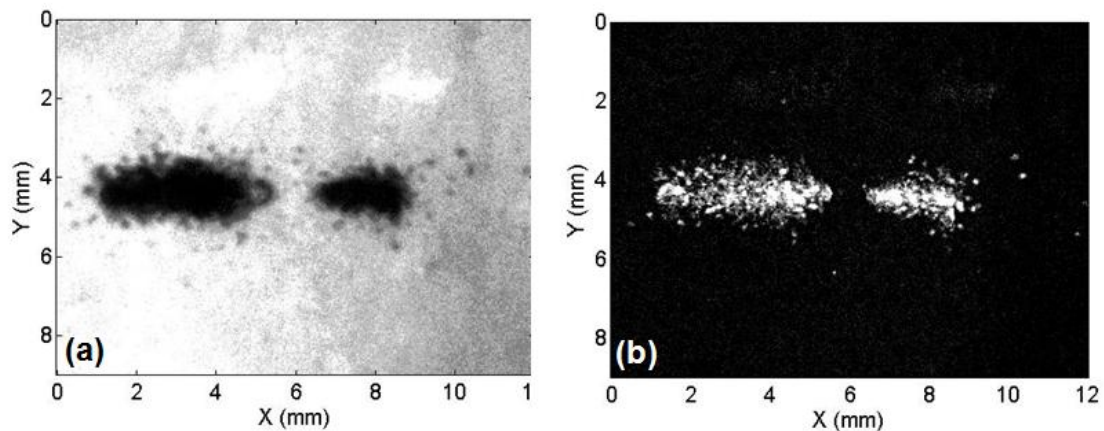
Examples of a bubble cloud and the corresponding lesion generated after ultrasound exposure. Ultrasound (US) propagation is from left to right. (a) High speed image of the bubble cloud $5 \text{ }\mu\text{s}$ after ultrasound pulse. (b) Subtraction image of the lesion generated by the single pulse. All lesions matched well in shape and dimensions with the corresponding bubble clouds. Lesions due to individual bubbles surrounding the focus are also evident.
